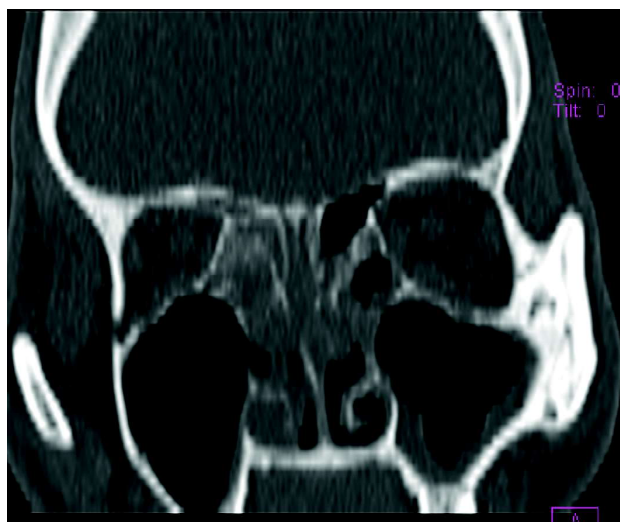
Axial and coronal reformatted CT images of the paranasal sinuses demonstrate obliteration of bilateral anterior and posterior ethmoid air cells by a soft-tissue density with mucosal thickening of bilateral maxillary sinuses involving the osteomeatal complexes. Soft-tissue thickening is seen in the nasal cavity as well as around the nasal septum with thinning of the septum.
